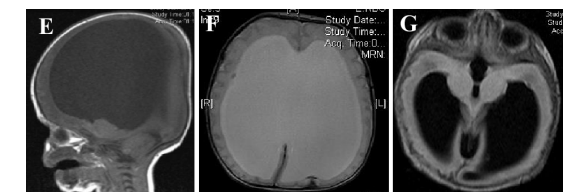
Figure (E-G) MRI images showing hydrocephalus.
